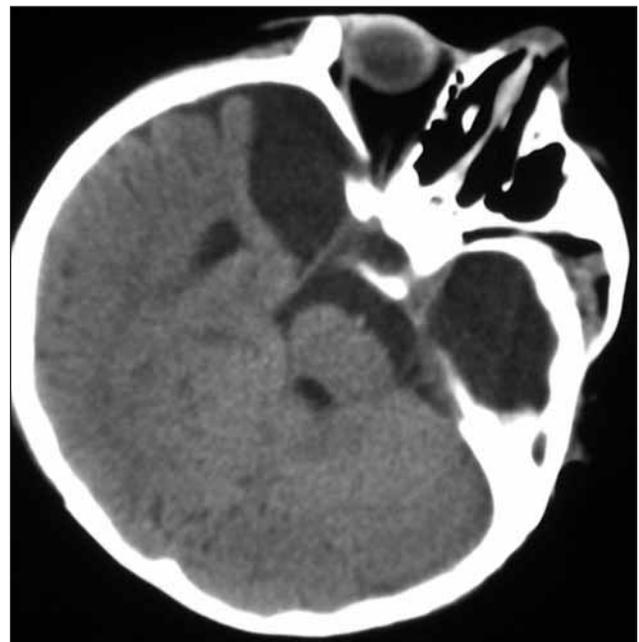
Axial CT showing bitemporal arachnoid cysts.
